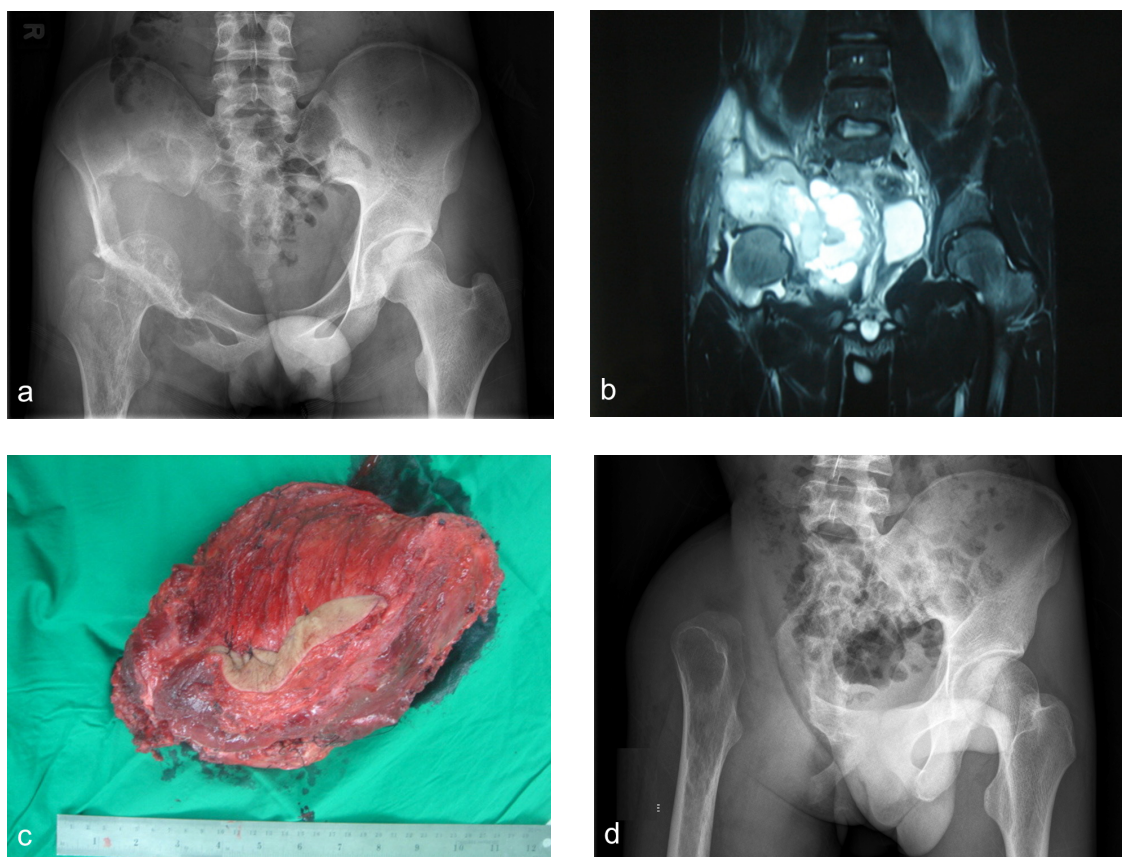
A 19-year-old male with MPNST with right pelvic bone destruction who underwent internal hemipelvectomy without reconstruction: A) Initial plain x-ray; B) Coronal view of T1-weighted MRI; C) Tumor mass after en-bloc resection; D) Postoperative plain x-ray
